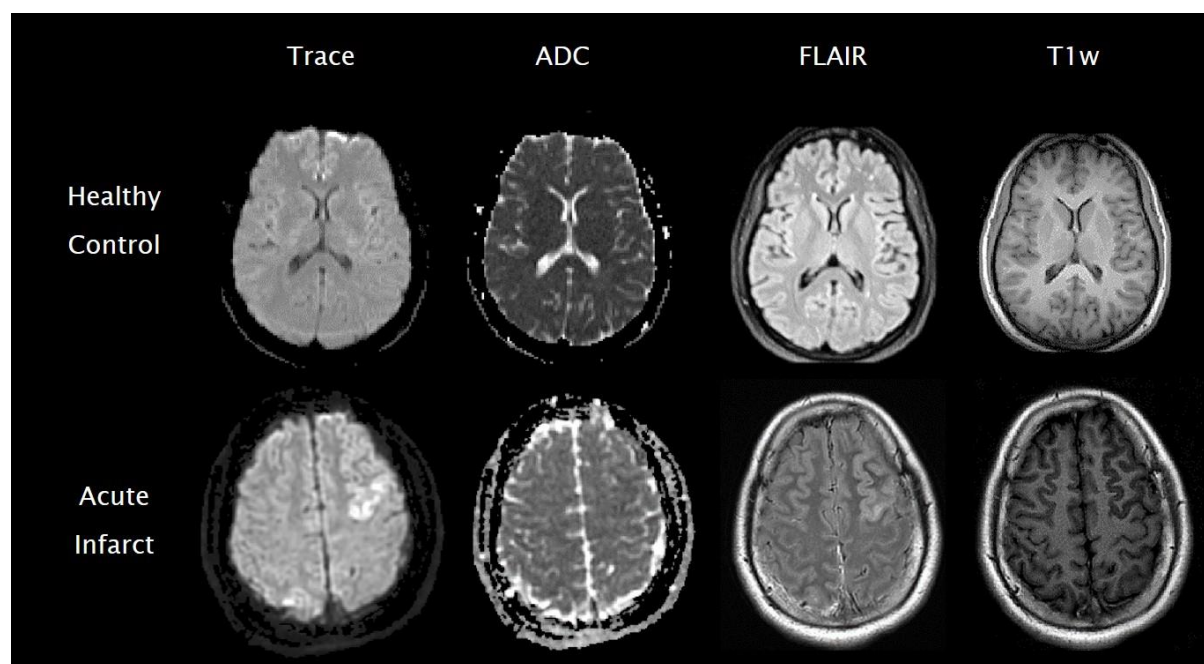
Examples of Trace, ADC, FLAIR and T1w images in the stroke dataset. The lesion is hyperintense on Trace but hypointense on ADC (Allen et al., 2012). On T1w, the lesion is more isointense than ADC and is faintly hyperintense on FLAIR.
